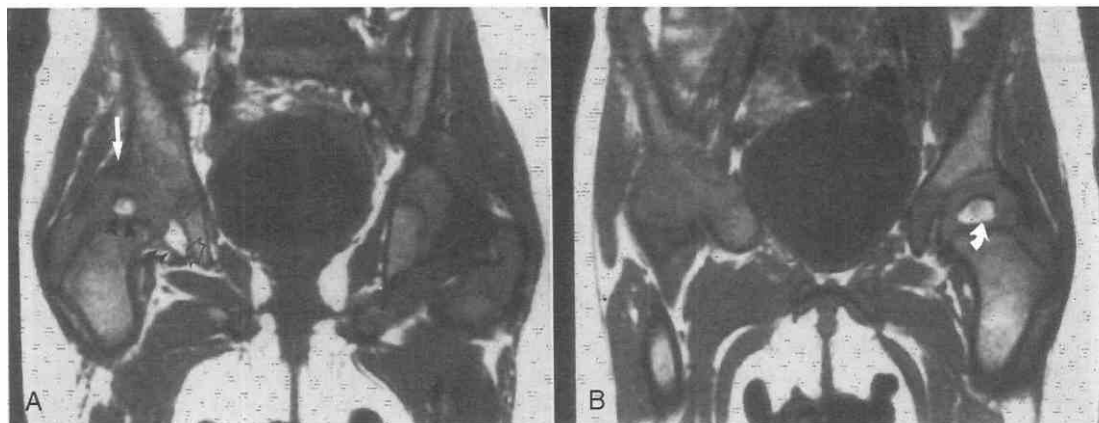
Developmental dysplasia of the right hip in a 12-month-old girl. *A* and *B*, Coronal T1-weighted MR images show delayed ossification of right capital femoral epiphysis (*large arrowheads*) compared with left side (*curved arrow*) and displacement superolaterally. Thickening of the fibrofatty pulvinar (*open arrow*), transverse acetabular ligament (*small arrowheads*), and ligamentum teres (*small arrows*) on the right has limited reduction of the hip; however, the acetabular labrum is not infolded (*large arrow*) to block reduction. (Courtesy of Edgar Colon, M.D.)
